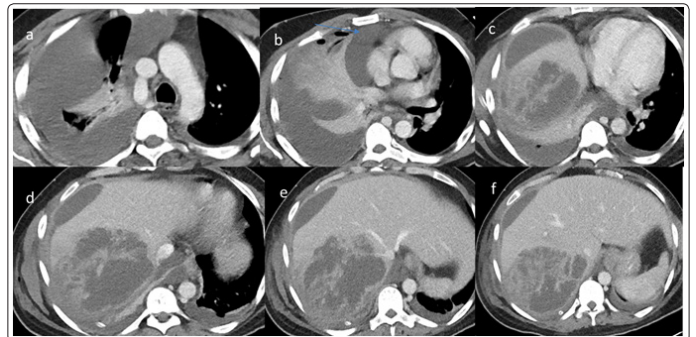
A: CT scan with intravenous contrast done after 10 days of first CT reveals re-demonstration of thin-walled abscess with internal necrotic debris in right lobe of liver. Increase in right pleural effusion with underlying collapse/consolidation, minimal left pleural effusion as well as pericardial effusion (arrow in image b). Sub diaphragmatic collection also seen.
